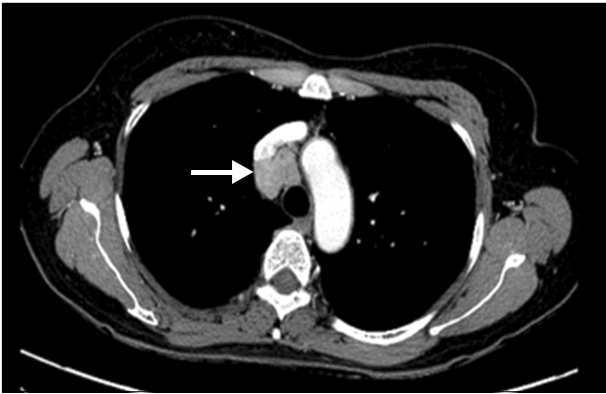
Preoperative heart contrast computed tomography scan shows round shaped mass in the right paratracheal area (arrow).
